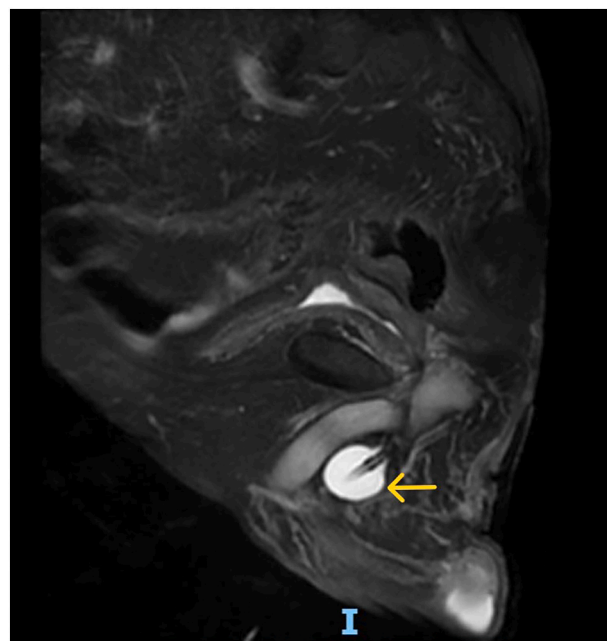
MRI of pelvis - T-2 weighted image (sagittal view) in a patient with tetraplegia and pressure sore posterior to the left ischial tuberosity and a track extending down to the hamstring muscle compartment, shows the surprise finding of Foley balloon filled with water seen as a bright circle in the penile urethra (arrow).
